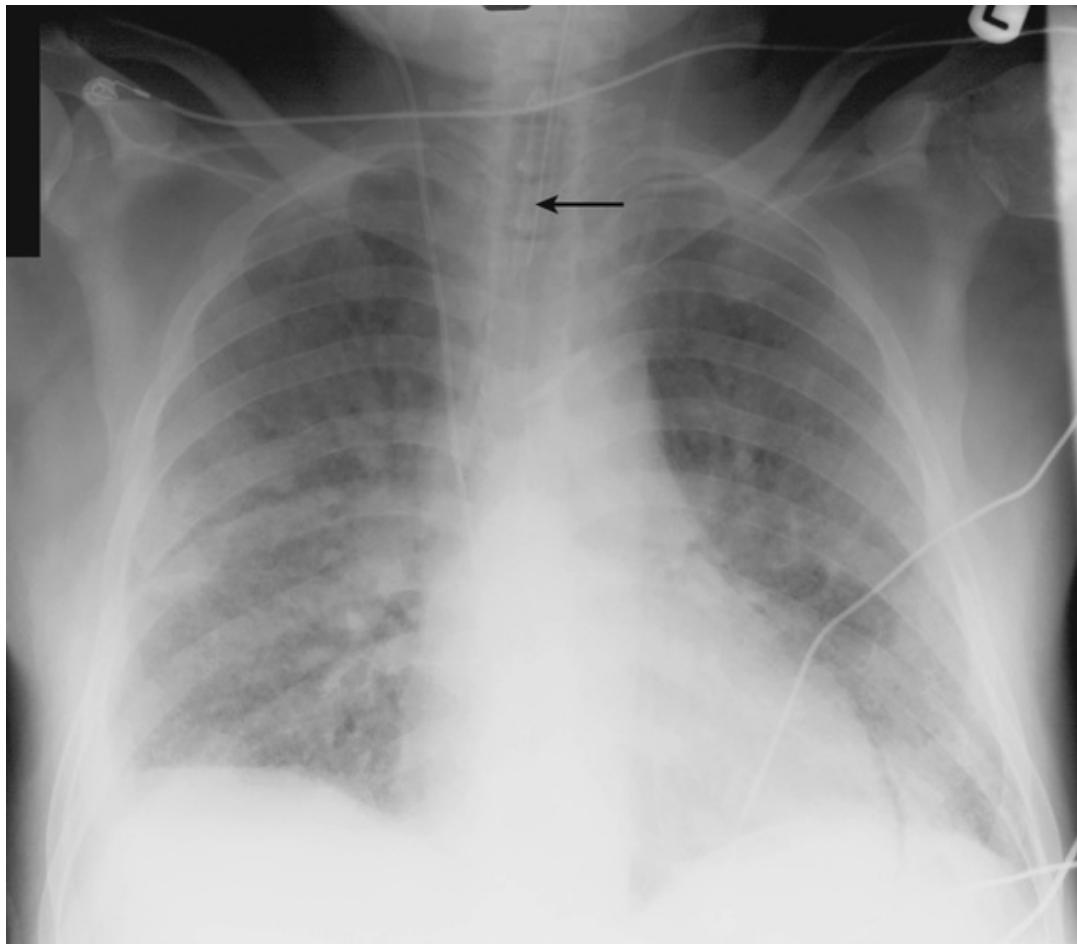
This 36-year-old man presented with severe upper abdominal pain and was diagnosed as having pancreatitis. Whilst in hospital he became acutely short of breath and required intubation and ventilation. Note the ET tube (arrow). A CXR was taken which suggested that he had developed the complication of acute respiratory distress syndrome (ARDS). Note that the x-ray shows multiple bilateral white shadows but does not have any signs of left ventricular failure. Unfortunately this man died after 3 weeks of mechanical ventilation on the intensive care unit.
